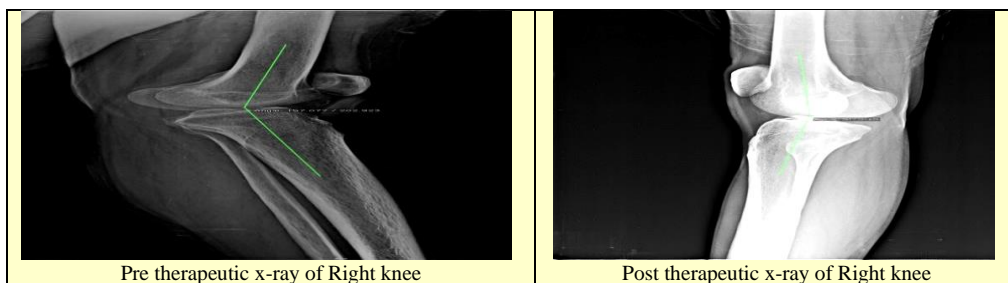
Shows Patient 5 Pre vs. Post Therapeutic X-ray of Right Knee
